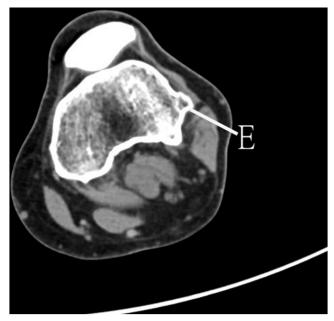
Endoscopic resection of distal femoral exostosis causing distal iliotibial band syndrome in left knee. The patient is in the lateral position. A transverse computed tomography image shows the exostosis (E) underneath the iliotibial band.
